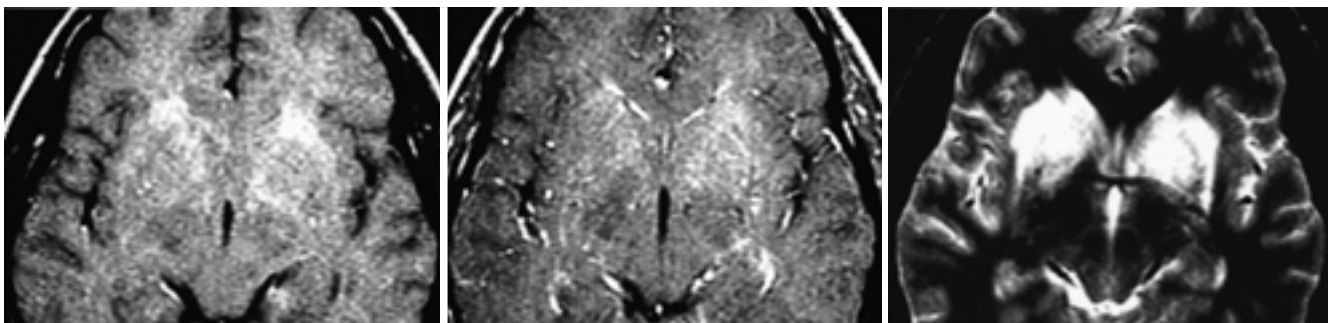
A 27-year-old woman with neuropsychiatric lupus. T1-weighted axial image (A) reveals ill-defined high signal intensity in both basal ganglia. Gd-enhanced T1-weighted axial image (B) reveals faint enhancement in both basal ganglia and intravascular enhancement. The homogeneous high signal intensities are seen in both basal ganglia on T2-weighted axial image (C).
